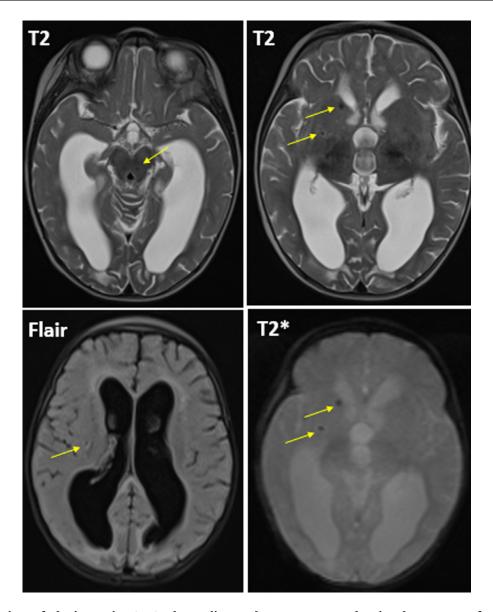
Axial sections of a brain MRI in T2, T2 echo gradient and FLAIR sequence showing the presence of multiple punctate subcortical, supratentorial, and infratentorial lesions, more marked on the right at the level of the head of the caudate nucleus, the pallidum, the internal capsule and the mesencephalic tegmentum, in T2 hyposignal and flair, surrounded by a thin border in T2 hypersignal (edema) and containing abnormalities in asignal on the T2 echo-gradient sequence related to central calcifications. There is moderate dilatation of the ventricular system with discrete signs of transependymal resorption.
